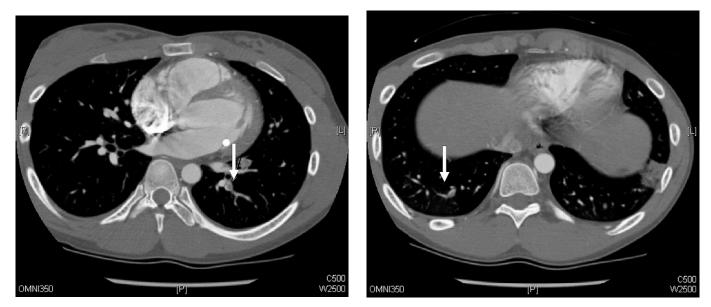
Computed tomography angiogram demonstrating filling defect.
